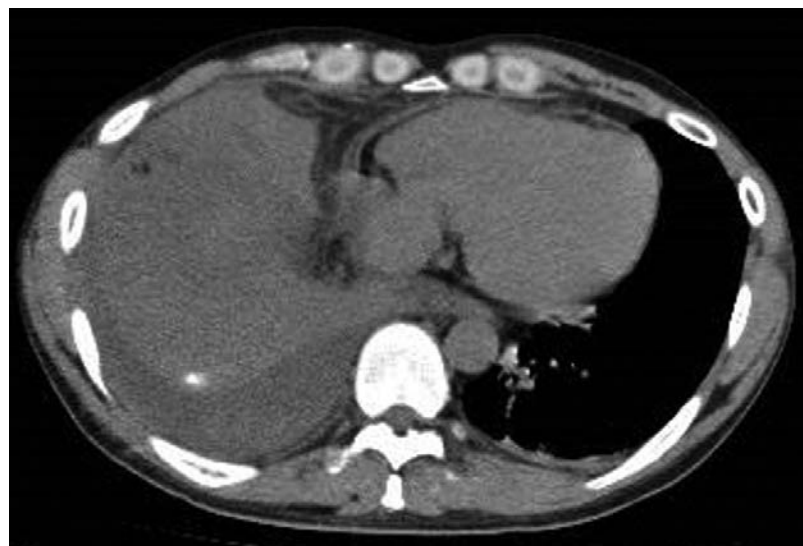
Chest computed tomography of calcified lung nodule and right massive pleural effusion.
